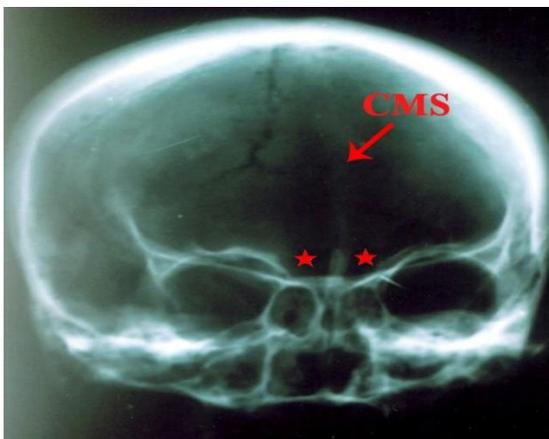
X-Ray skull showing complete metopic suture (CMS) with bilateral absence of frontal air sinuses (*)
